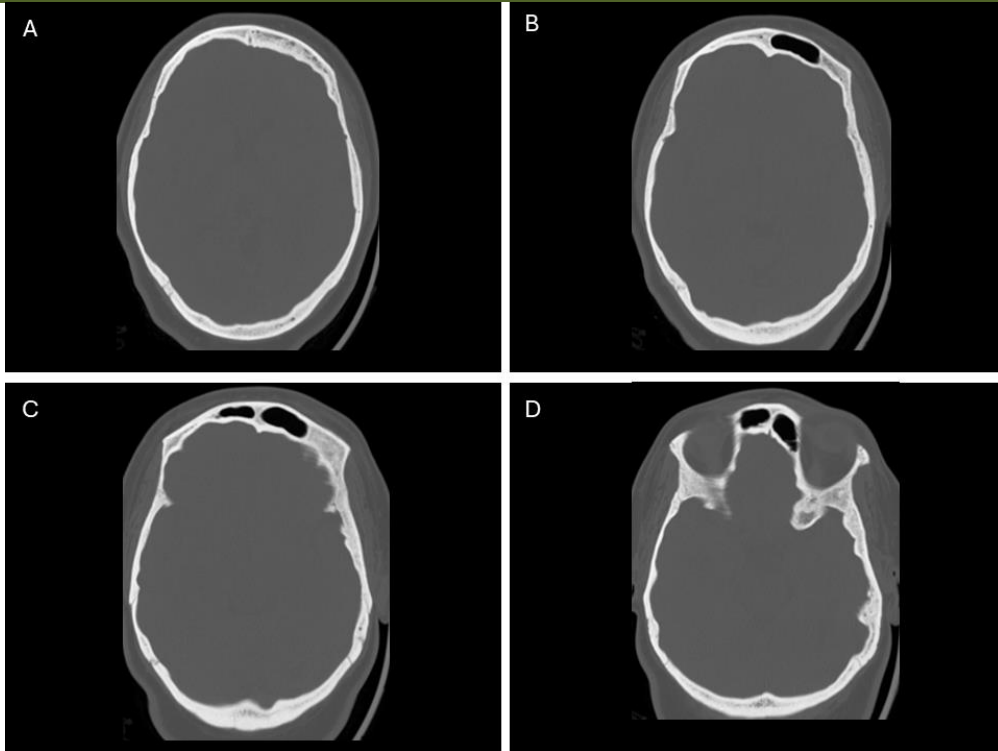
Bone window brain CT images
